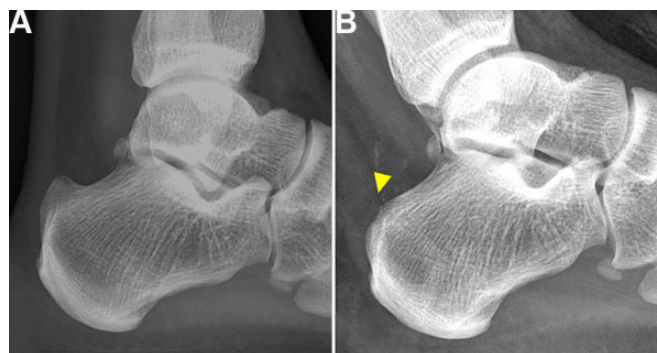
(A) Preoperative simple lateral-view radiograph showing a prominent posterosuperior calcaneus. (B) Postoperative radiograph showing resected calcaneal tubercle and decompression of retrocalcaneal recess (arrowhead).
